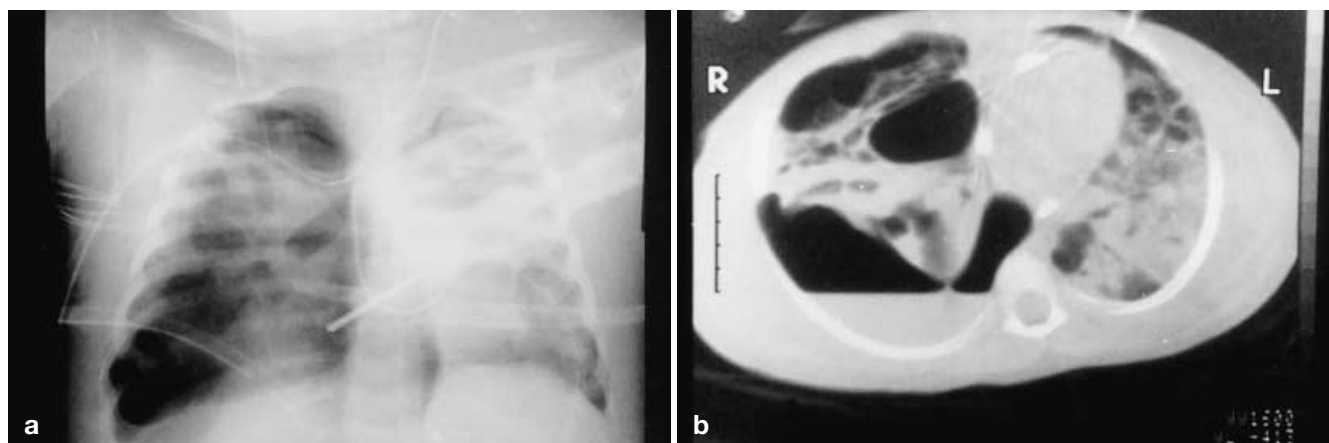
Images taken from a nearly drowned 3-year-old girl who was resuscitated and subsequently developed ARDS, for which she required extracorporeal carbon dioxide removal. (a) The distribution of the pneumothorax appears to be totally unpredictable from the plain chest X-ray: chest tubes are unable to drain the air collection; (b) a CT scan shows posterior hydropneumothorax in the right hemithorax with pulmonary collapse associated with a right anterior pneumothorax. Bilateral opacities with bullae are diffusely represented
